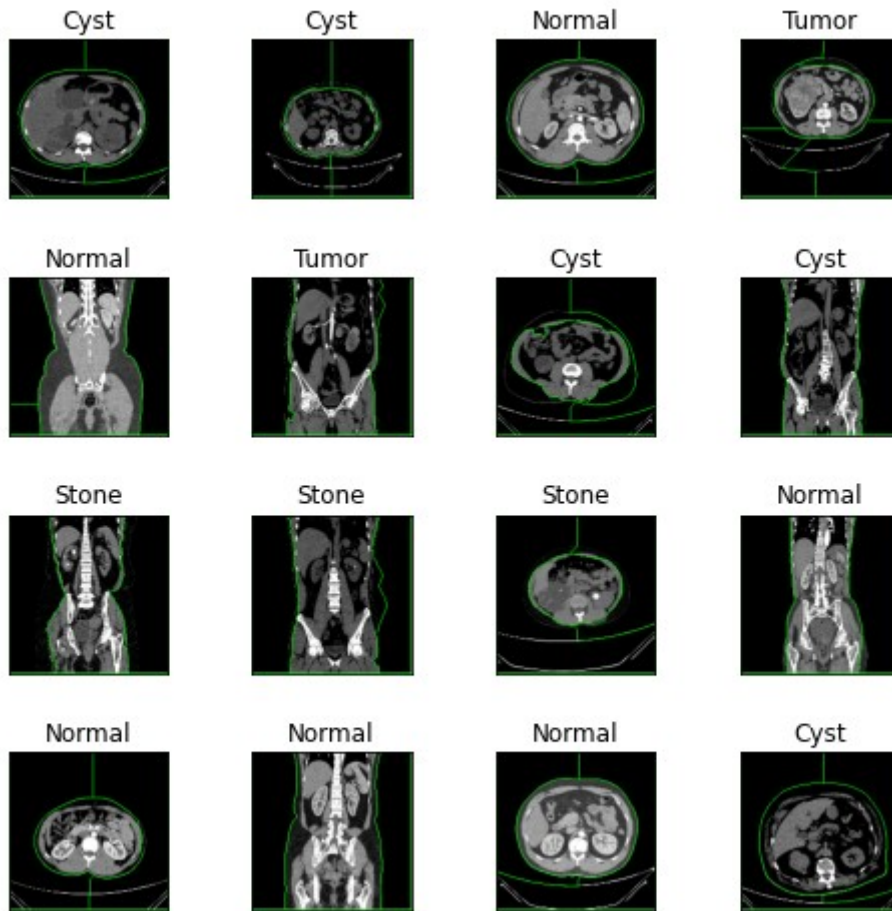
CT images after applying Watershed segmentation.
